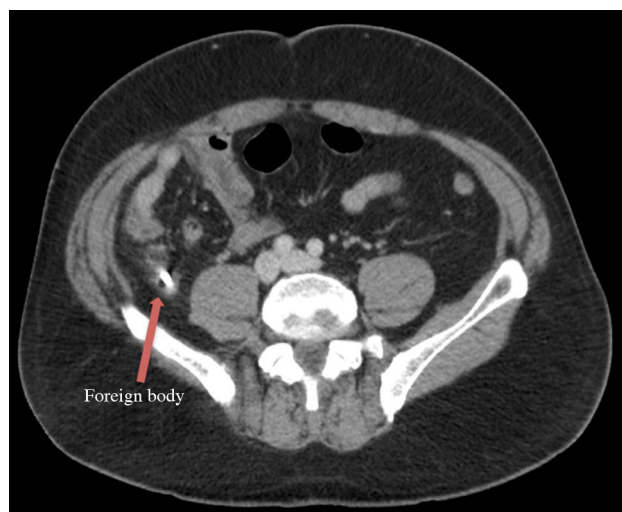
Abdominal CT scan: a metallic foreign body can be seen in the caecal appendix with associated inflammatory changes consistent with acute appendicitis.
